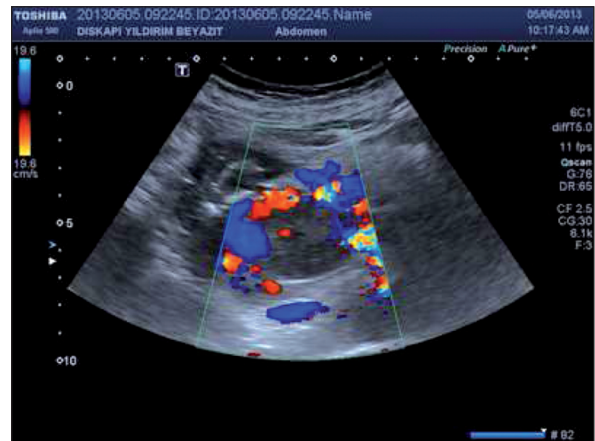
Colour Doppler ultrasonography of portal region: Axial image. Increase in the portal vein diameter and hypoechoic thrombus formation in the vassal lumen.
